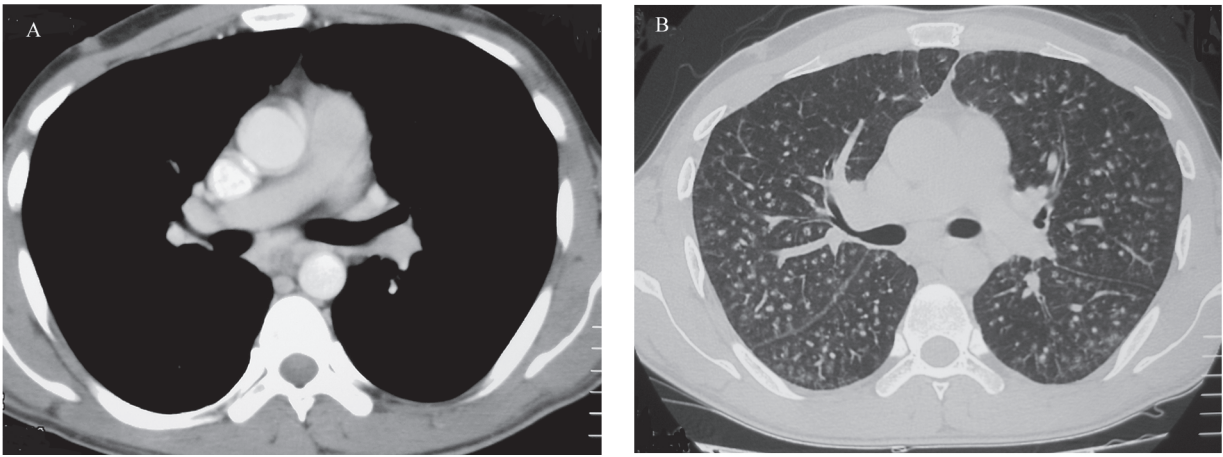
A) Hilar and mediastinal lymph nodes in follow-up CT; B) parenchymal nodular lesions in follow-up CT.
